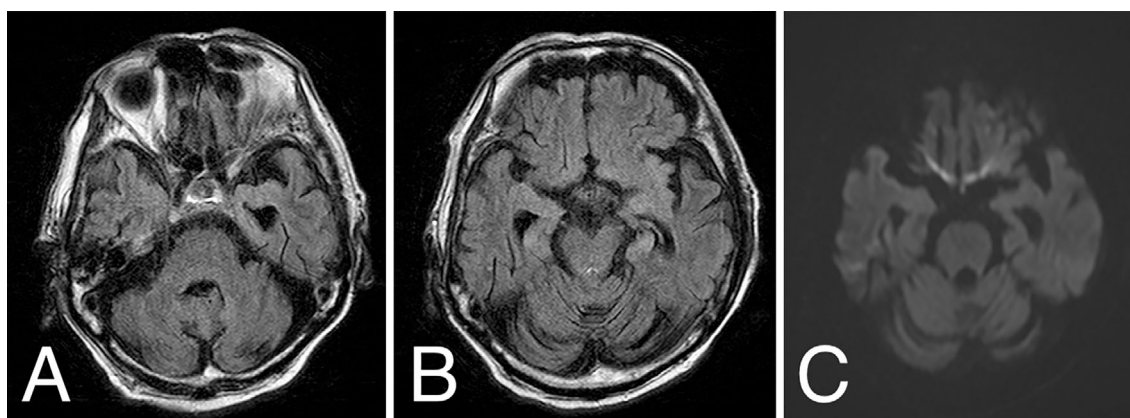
Brain magnetic resonance imaging findings for an elderly patient with a progressive neurological disorder who developed a condition mimicking acquired laryngomalacia; (A, B) Cerebellar atrophy on FLAIR, (C) No abnormal signals on DWI.
